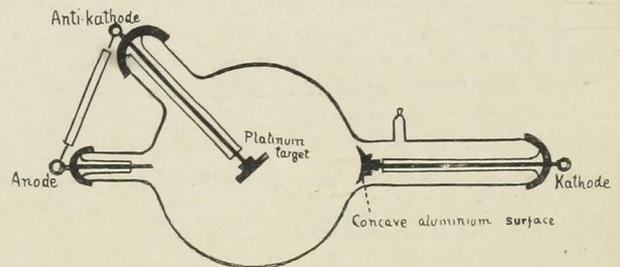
SIMPLE FORM OF X-RAY "TUBE" OR LAMP.
